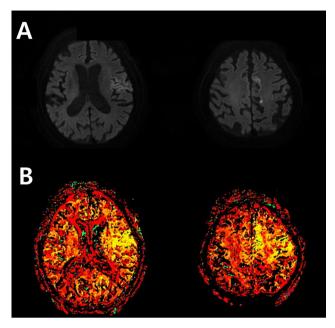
Initial magnetic resonance imaging after ischemic stroke. (A) Axial diffusion-weighted imaging demonstrating diffusion restriction in the left anterior cerebral artery (ACA) and middle cerebral artery (MCA) territories. (B) Perfusion imaging showing a region of decreased perfusion within the left MCA and ACA territories
